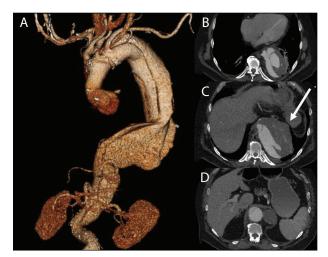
CTA showing a contained rupture of a post–type A thoracoabdominal aneurysm (TAA). The rupture is seen in the descending thoracic aorta. Three-dimensional (3D) reconstruction of the rupture (A). Axial CTA showing multiple lumens in the thoracic aorta (B). Axial CTA showing the contained rupture (arrow) (C). Axial CTA showing our intended distal landing zone above the celiac trunk (D).
